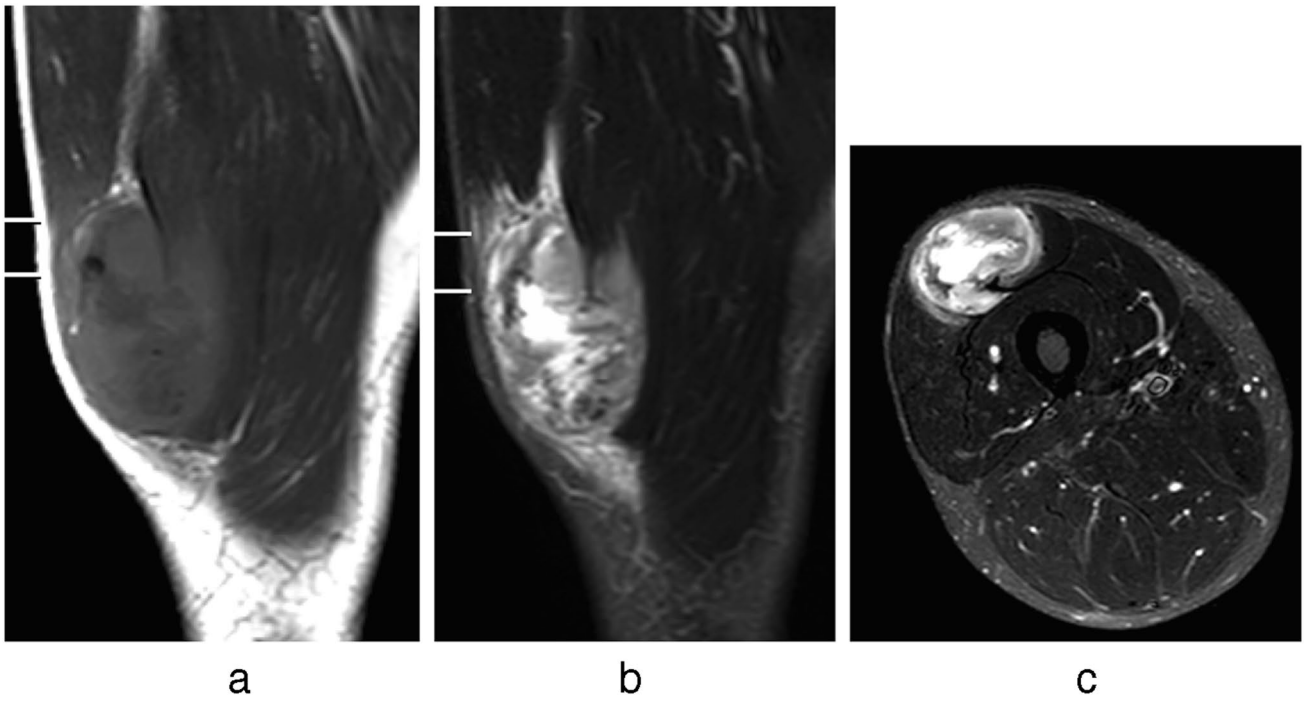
a Coronal T1W TSE and b coronal and c axial STIR MR images of the right thigh
